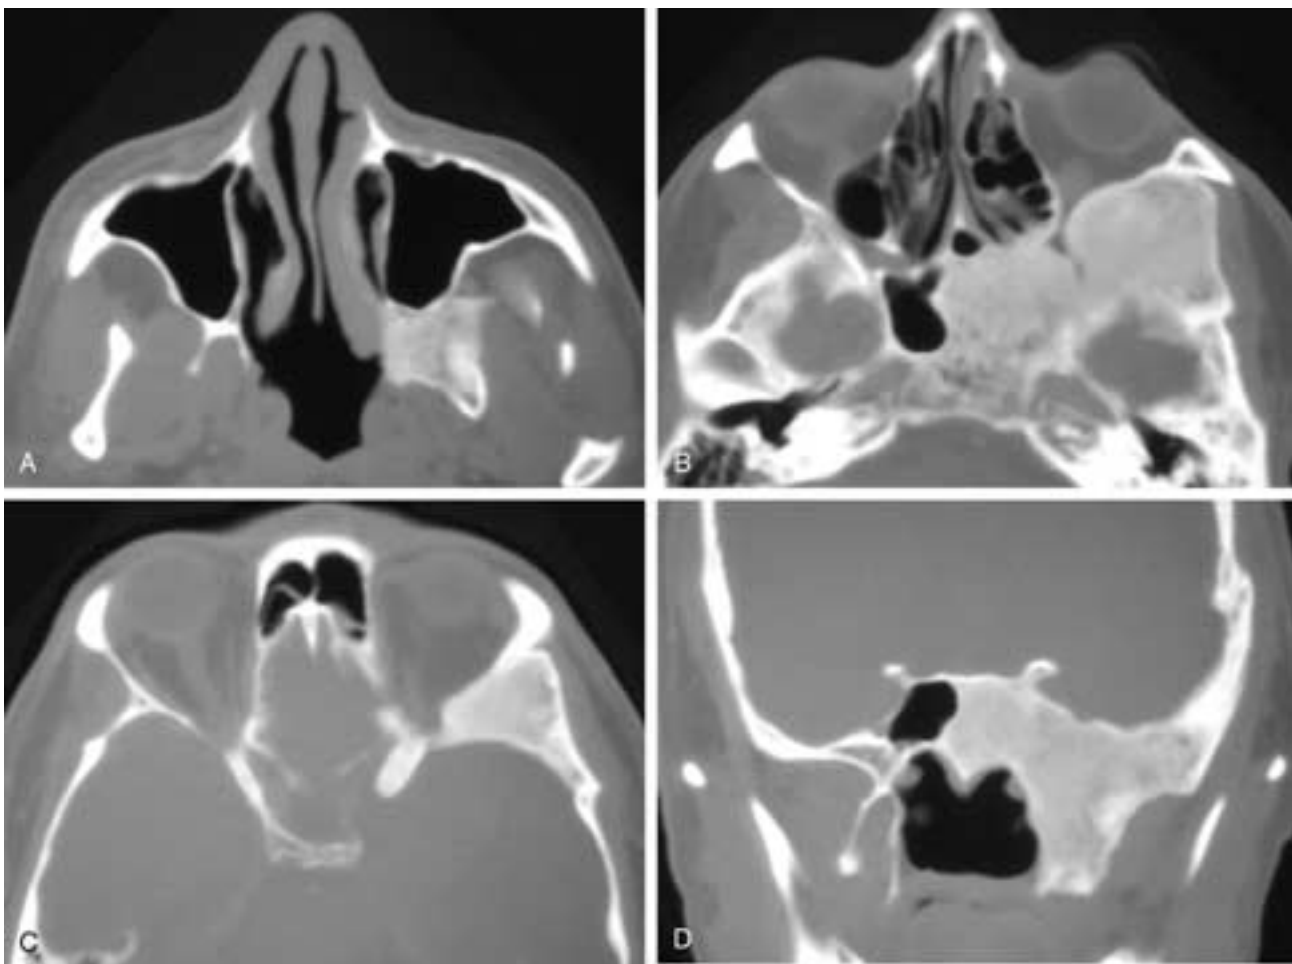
Serial axial CT scans (A through C) and coronal CT scans (D) show a “ground glass” expanded left sphenoid bone. The left sphenoid sinus is obliterated, and all portions of the bone are affected.
